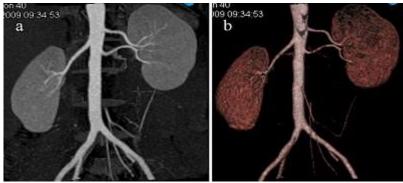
CT Angiography shows normal vasculature of kidneys.
